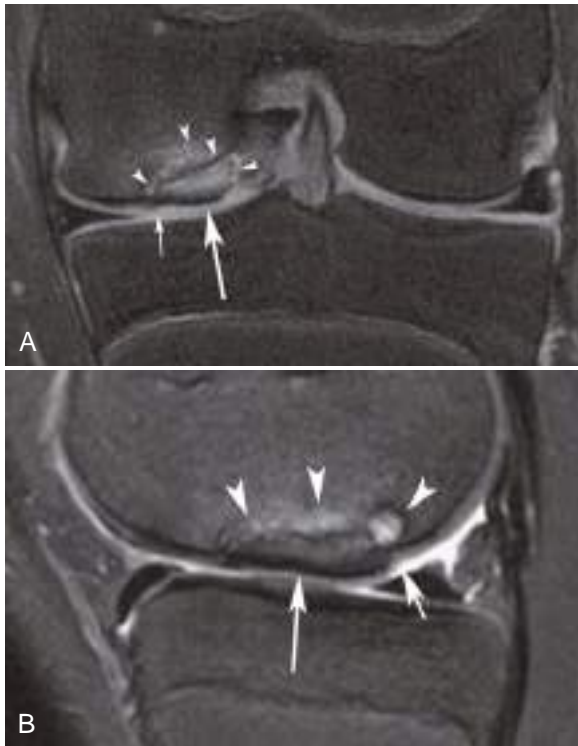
Osteochondritis dissecans (OCD) with loose in situ fragment. MRI findings in a loose fragment are not always as unambiguous as seen in Fig. 1.93. Coronal fat-suppressed proton-density (A) and sagittal fat-suppressed T2-weighted (B) MR images of the left knee show medial femoral condyle OCD fragment (*large arrow*), with surrounding high signal, small cystlike lesions, and marrow edema at the margin of the fragment and the host bone (*arrowheads*). Also note the small articular step-off posteriorly (*short arrows*). These findings are highly suggestive of a loose fragment, but a fragment that is healing in place could have a similar appearance. Arthroscopy was needed to confirm that this fragment was loose in situ.
